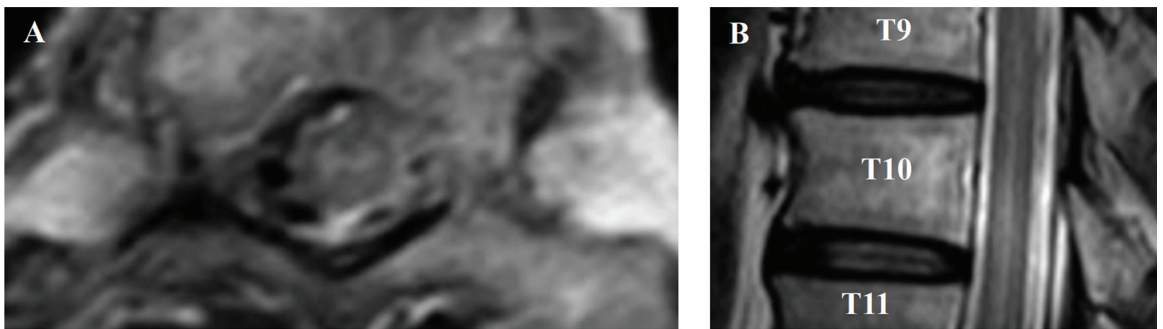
Axial T2-weighted magnetic resonance image of thoracic spine in level of T9 showed focal hyperintense lesion involving anterior and central aspect of spinal cord (A). Figure A showed magnified images of the affected spinal cord (A). Sagittal T2-weighted magnetic resonance image of thoracic spine in the correspondent level also showed linear hyperintense lesion involving anterior aspect of spinal cord resembling 'pencil sign' in T9-T11 level (B).
